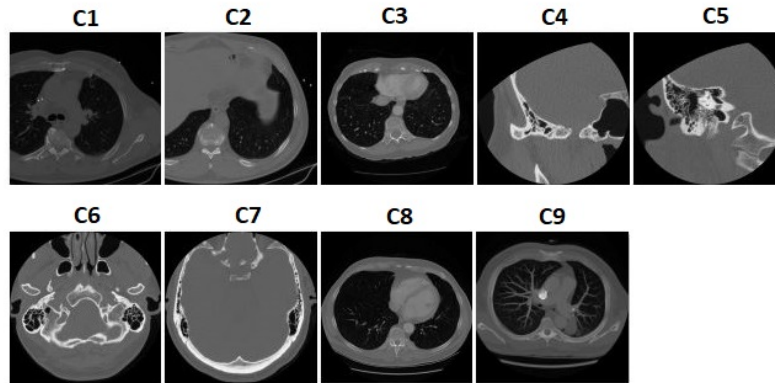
Sample images from each class of NEMA-CT dataset.
